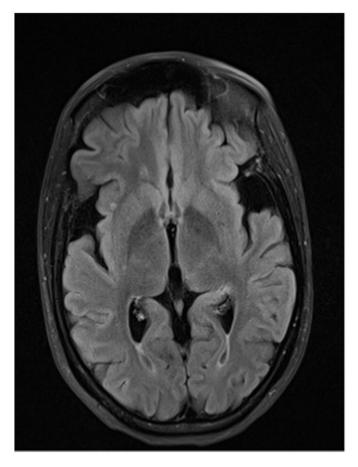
MRI features of patient 1. Fluid attenuated inversion recovery image demonstrating enlarged sylvian fissures.
